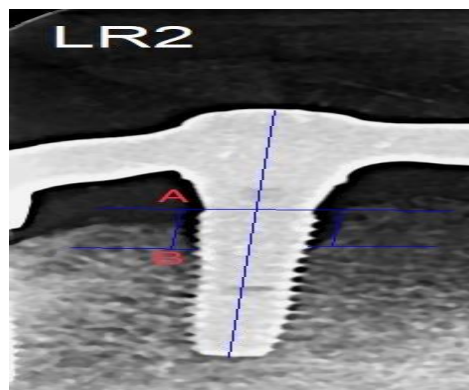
Tracing of the bone loss on periapical film.
